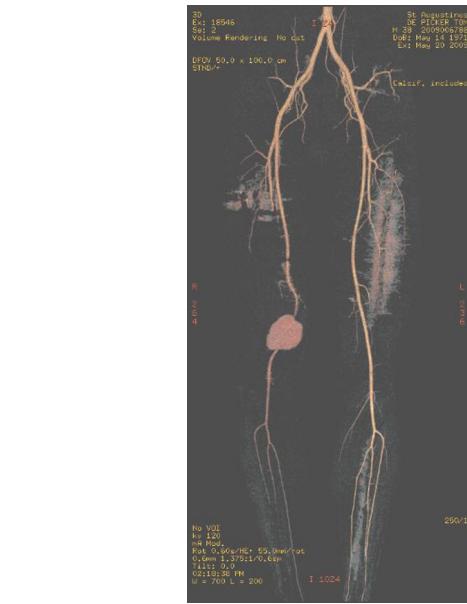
CT angiography of the lower extremities showing contrast extravasation, confirming the diagnosis of false aneurysm of the superficial femoral artery.
